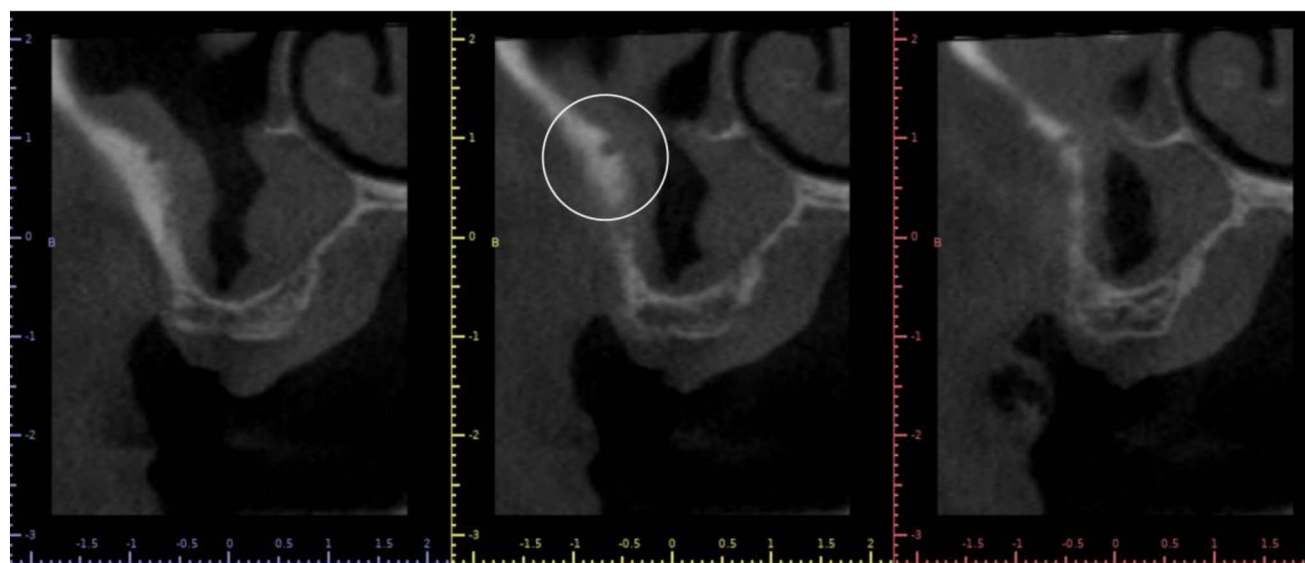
The coronal cut of a cone-beam computed tomography image indicating right-side sinus anatomy. Predicted location of the alveolar antral artery (lucency) within the bone structure of the lateral wall (white circle).
